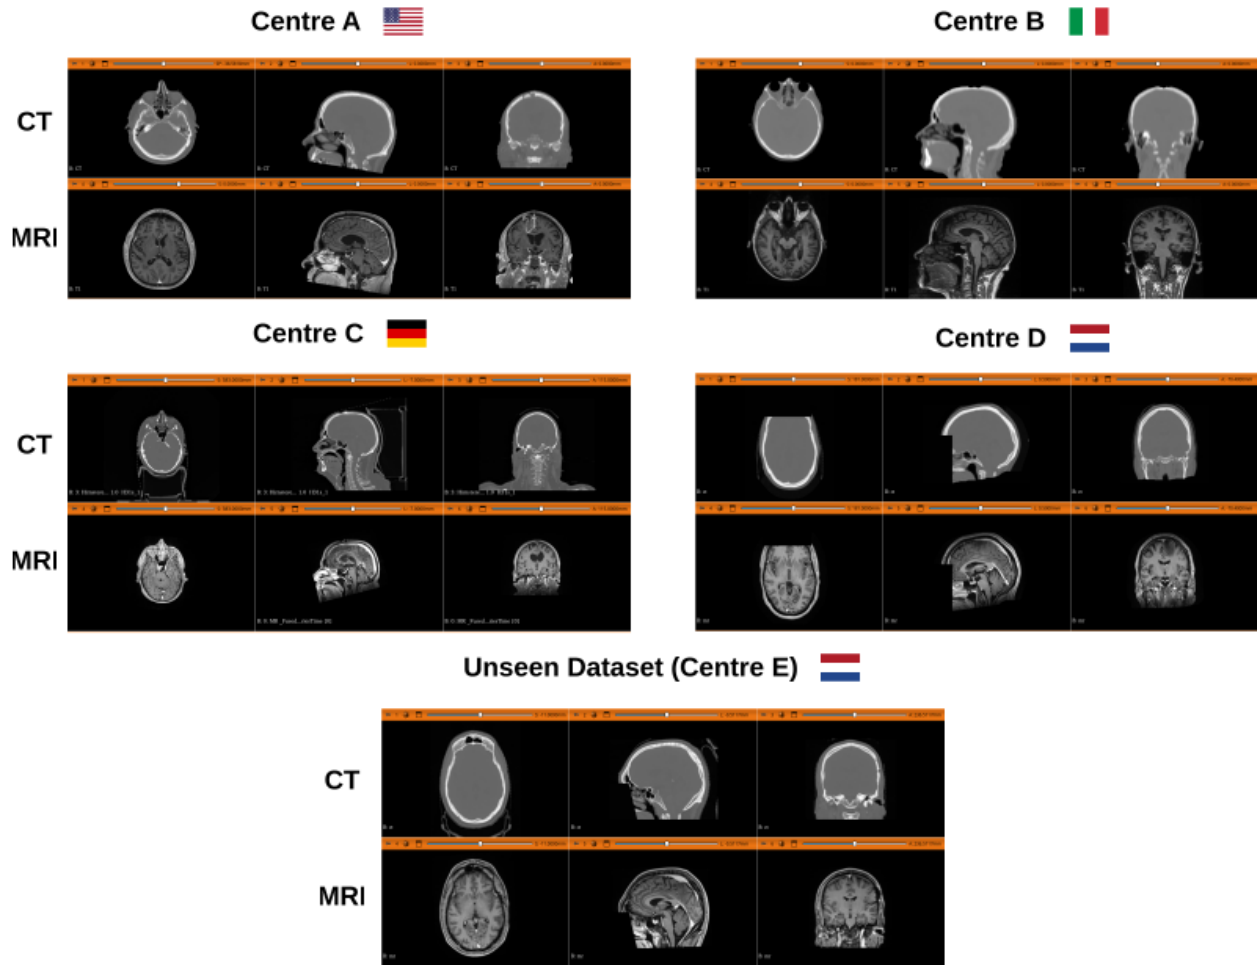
Visual comparison of image appearance across datasets from multiple Centres. The FOV of the images from Centre A was limited to the level of the mouth and included partial cut-off of the ears. Images from centre B were acquired using a PET-MRI hybrid scanner. Furthermore the higher CT slice thickness introduced partial volume artefacts in the skull bone reconstruction. Images coming from centre C exhibited higher spatial resolution in the cranial caudal direction, but presented other problems, including partial cropping at the top of the skull and metal artefacts. Centres D and E—derived from SynthRAD2023 challenge—shared similar imaging regions with less bias fields compared to Centre C.
